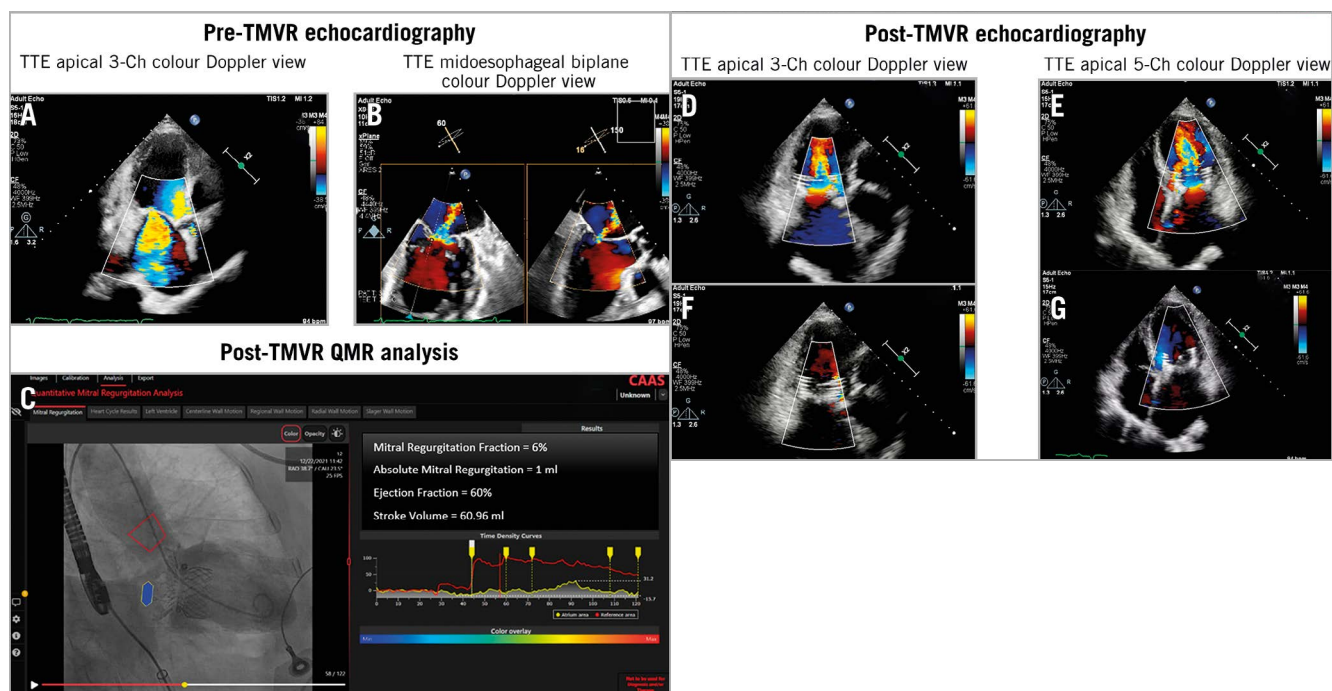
Multi-imaging modality assessment of the mitral valve during TMVR with the HighLife mitral valve. A-B) The transthoracic echocardiography (TTE) 3-Ch colour Doppler view and the transoesophageal echocardiography (TOE) X-plane view show severe mitral regurgitation before TMVR. C) Quantitative angiography of residual mitral regurgitation after TMVR using videodensitometry. D-G) After TMVR, transthoracic echocardiography 3-Ch and 5-Ch views in diastole and systole with colour Doppler shows a well-functioning prosthetic mitral valve. Ch: chamber; QMR: quantitative mitral regurgitation; TMVR: transcatheter mitral valve replacement
